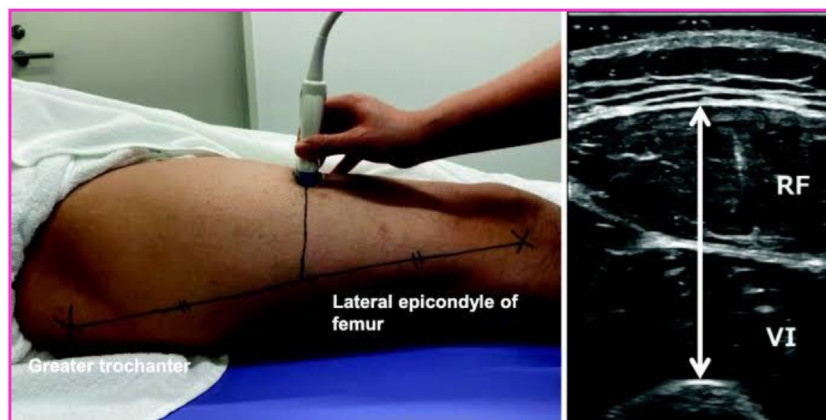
Measurement of rectus femoris thickness by ultrasound.
